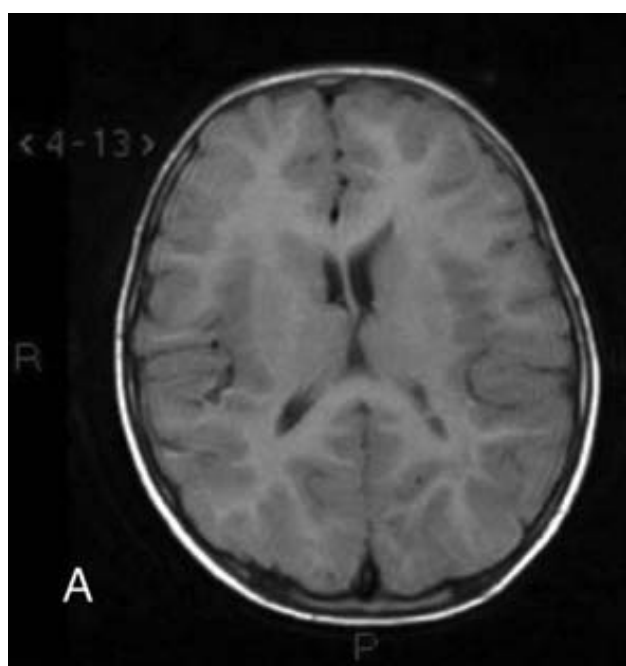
Cortical Tubers MRI (A: T1, B: T2, C: Flair)
